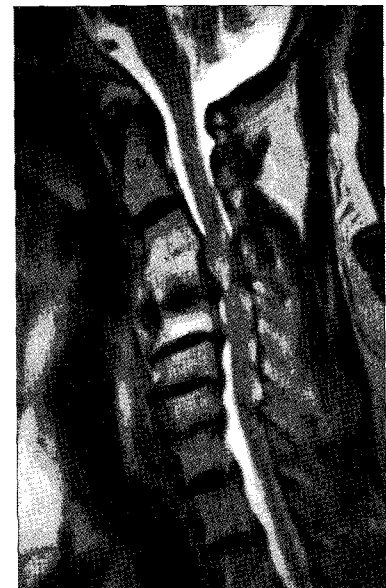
Preoperative cervical spinal magnetic resonance image showing the congenital block at vertebrae C3-4 and severe degenerative spinal stenosis with compressive myelopathy at C4-5.
